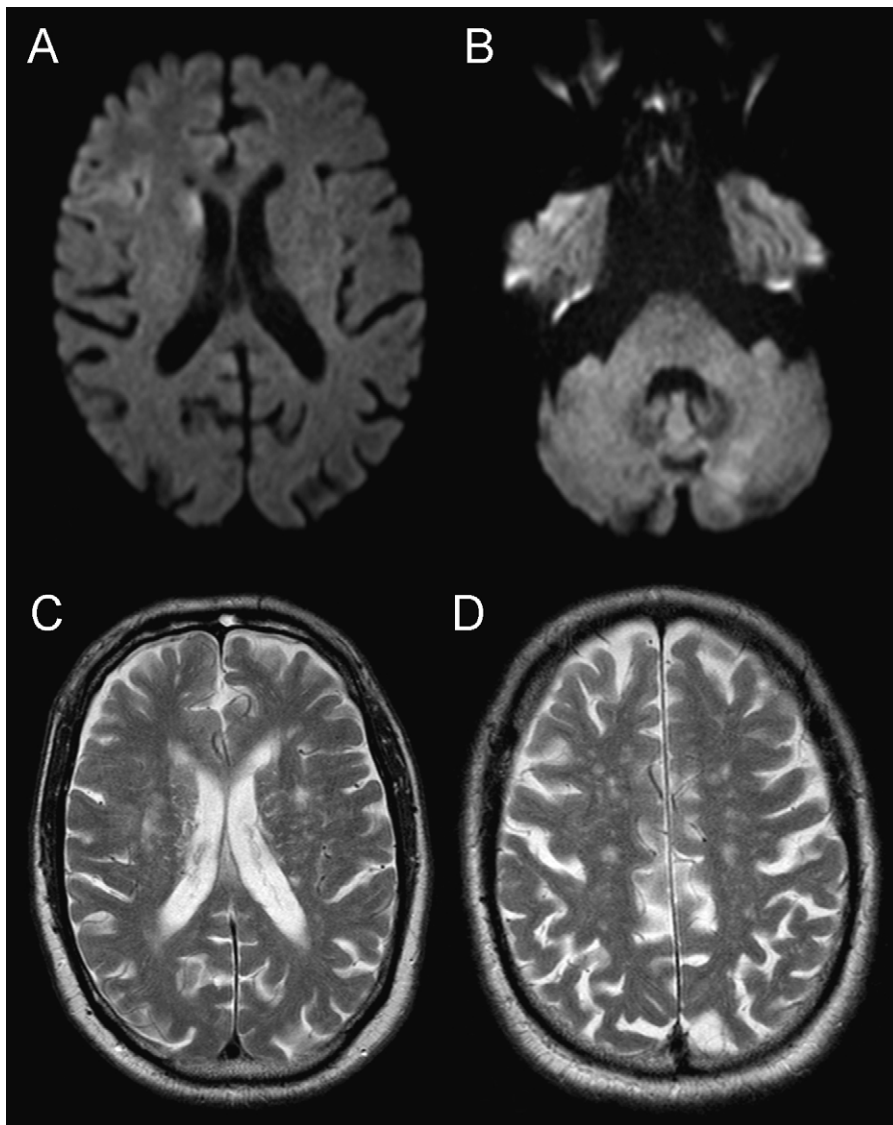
Initial cerebral magnetic resonance imaging (MRI). On diffusion-weighted sequences (A and B), two hyperintense lesions were noted in the right caudate nucleus (A) and the left cerebellar hemisphere (B) with a decreased attenuated apparent diffusion coefficient. On T2-weighted sequences, multiple bilateral deep hyperintense lesions were found (C and D).
